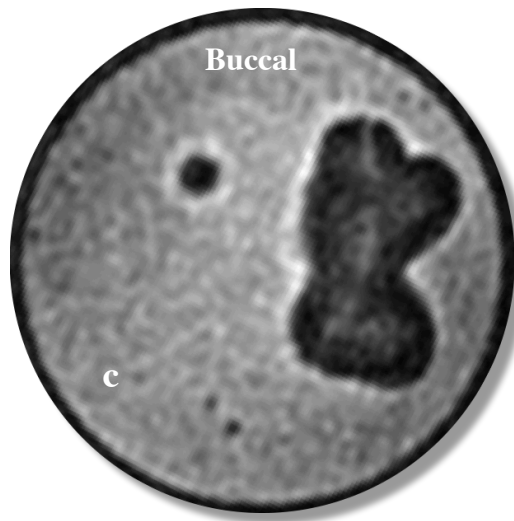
Maxillary 2nd molar with VRF progressing from lingual to buccal root surfaces. Selected corresponding axial slices: SWIFT MRI (c) with notable absence of artifact from radio-dense root filling materials, and limited FOV CBCT (d) with moderate, radio-dense root filling material-associated artifacts and beam-hardening artifacts.
